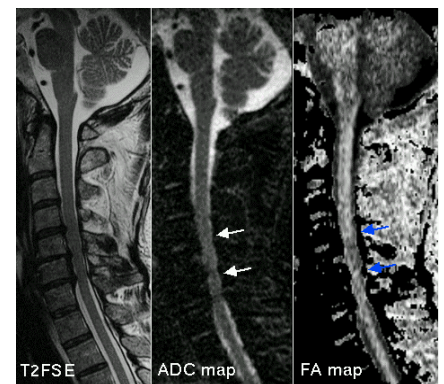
Patient without abnormal signal on T2-weighted image demonstrates slightly elevated ADC and decreased FA in the segment between the arrows.
